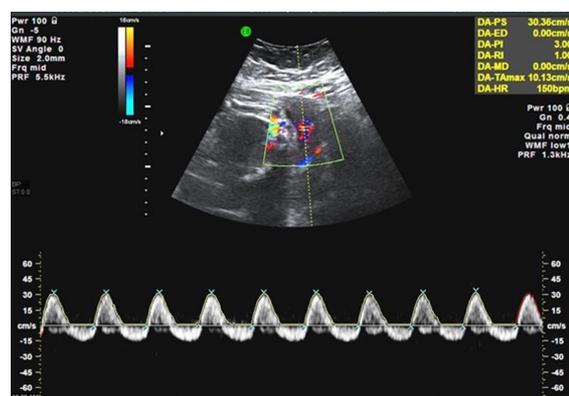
Abnormal color Doppler umbilical artery waveform demonstrating reversed end-diastolic frequencies.
